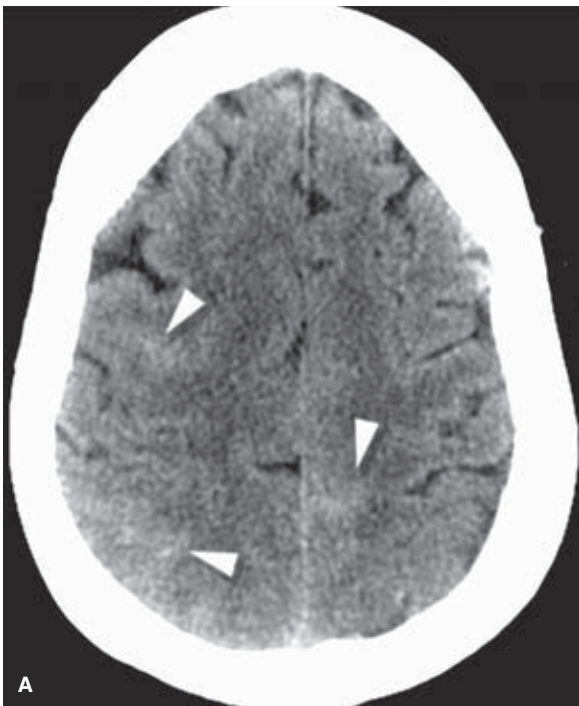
(A–B) Nonperimesencephalic subarachnoid hemorrhage. A female patient in her early fifties complained of a week of crescendo headache and was found to have evidence of subarachnoid hemorrhage on CT (*arrowheads* in A) over the convexities. No aneurysm was found and no history of substantial head trauma was forthcoming. Angiography demonstrated (*arrowheads* in B) multiple areas of luminal constriction in the medium-sized vessels of the anterior and posterior circulation. These findings and her clinical symptoms were ascribed to RCVS.
